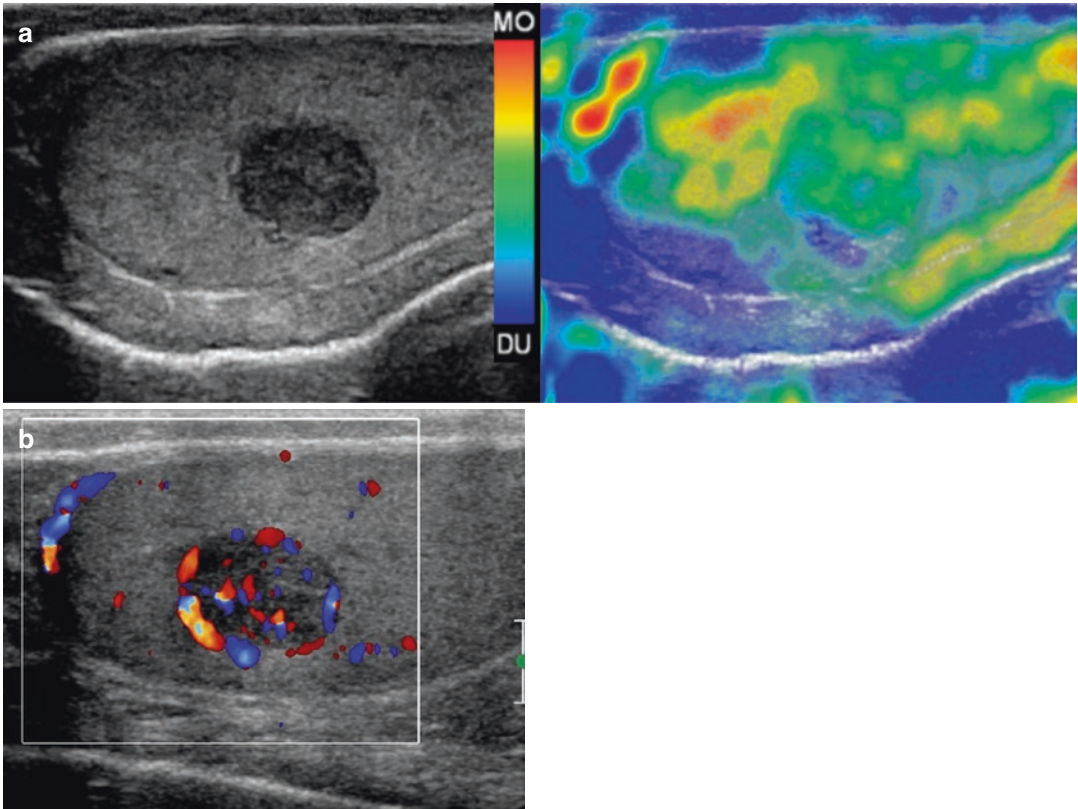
(a, b) A 32-year-old infertile patient with a hypoechoic, non-palpable lesion of 1 cm, soft at elastography (a). The lesion is markedly vascularised at colour Doppler interrogation (b)
